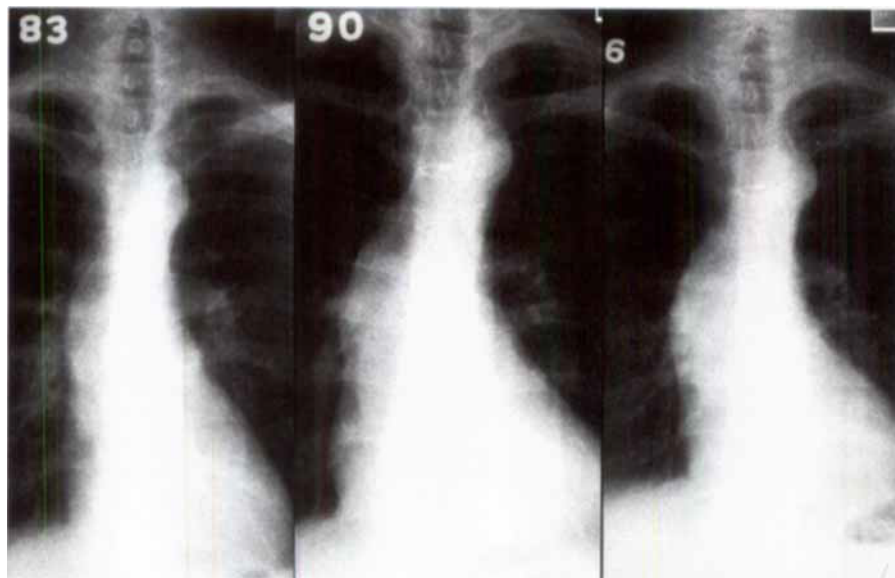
Serial chest x-rays in Case No. 2: 2 years prior to aortic valve replacement, 4 years after and 10 years after (left to right). Note increasing prominence of ascending aorta.
